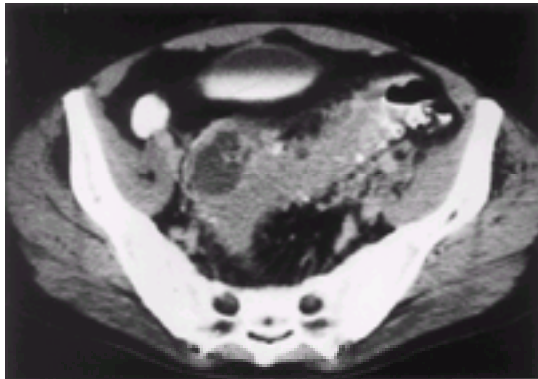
CT scan showing sigmoid diverticulitis and pelvic abscess.
